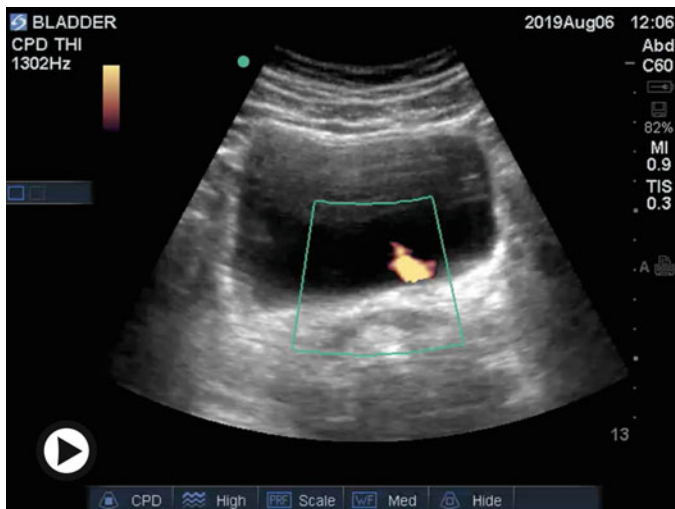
(Video 7.1) Video of a bladder in the transverse plane, with yellow ureteral jets demonstrated with the use of color power Doppler (► <https://doi.org/10.1007/000-7qd>)
